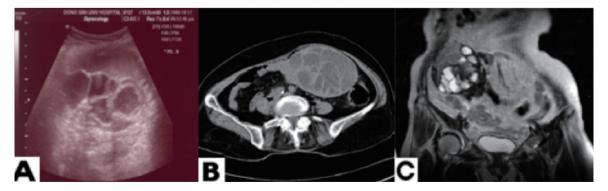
A: Transvaginal ultrasound examination showed multiseptated huge mass in right adnexa. B: Abdominopelvic computed tomography showed a large ovoid multiseptated cystic mass of right ovary, suspicious of mucinous cystadenoma. C: Magnetic resonance imaging of pelvis showed a large ovoid multiloculated cystic mass in right adnexa.
